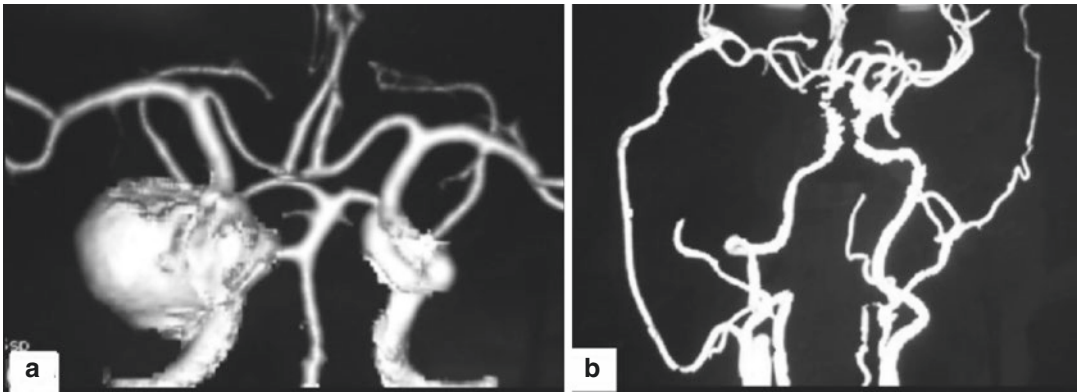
(a) Shows CTA with a giant right cavernous ICA aneurysm. (b) Shows complete obliteration following ECIC bypass with RAG & ligation of ICA in neck
